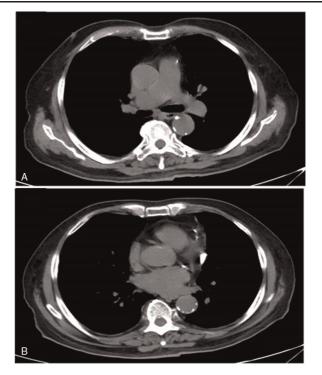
(A and B) Chest CT at 12 weeks after initiation of pembrolizumab demonstrating resolution of bilateral pulmonary masses. CT=computed tomography; PSA=prostate-specific antigen.
